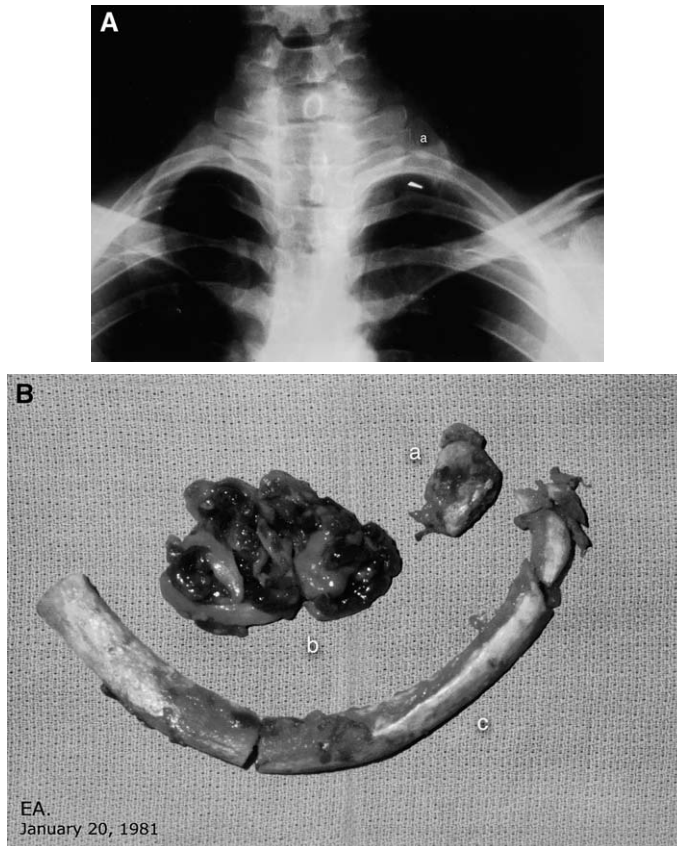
This female patient had a left transaxillary first rib resection. She developed marked recurrent symptoms of lower type (C8–T1) TOS 6 months after surgery. (A) Radiography reveals 1-inch remaining left first rib posteriorly (a). (B) Patient had reoperation that consisted of transaxillary resection of the remaining 1-inch first rib (a) and middle scalene muscle (b) with external neurolysis of the lower brachial plexus and vasolysis of subclavian vessels. Most of the second rib (c) also was removed at the same time. The patient had very good relief of symptoms. (From The Christine M. Kleinert Institute for Hand and Microsurgery, Inc.; with permission.)
